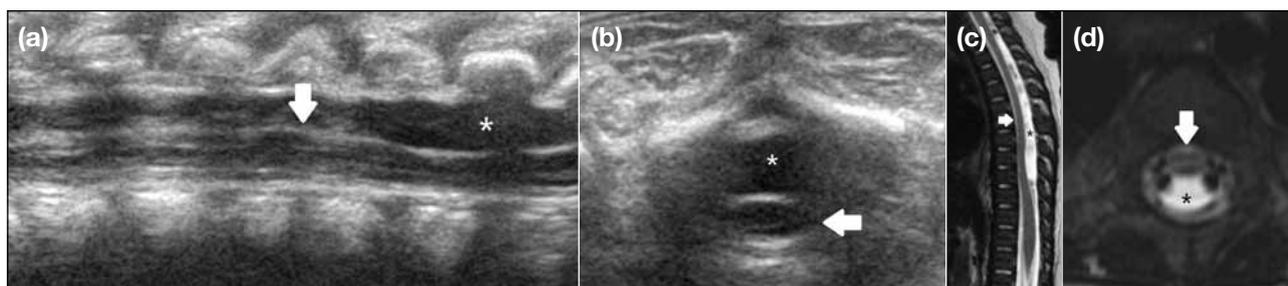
(a) Longitudinal, and (b) transverse ultrasonography shows a small fusiform well-defined cystic extramedullary lesion (asterisks) at the dorsal aspect of the thoracic cord (arrows), suspicious of an arachnoid cyst. Corresponding T2-weighted magnetic resonance imaging (c) sagittal and (d) axial images demonstrate the cerebrospinal fluid content and extramedullary location of this lesion (asterisks) at the dorsal aspect of the thoracic cord (arrows), thus confirming the diagnosis.
